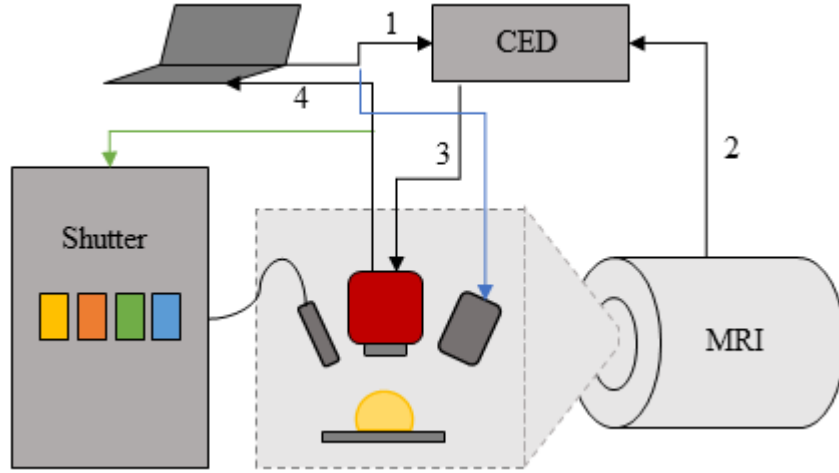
Acquisition setup. The computer loads a pre-configured trigger sequence to the CED (1). Once the MRI acquisition begins, it triggers the CED (2) to start playing the pre-configured sequence which runs the camera at the desired frequency (3). For an OIS acquisition, the camera triggers the switching galvanometer to switch filter between each image (Green). For an SFDI acquisition, the computer controls the image displayed onto the sample (Blue). The images are collected on the computer (4).
